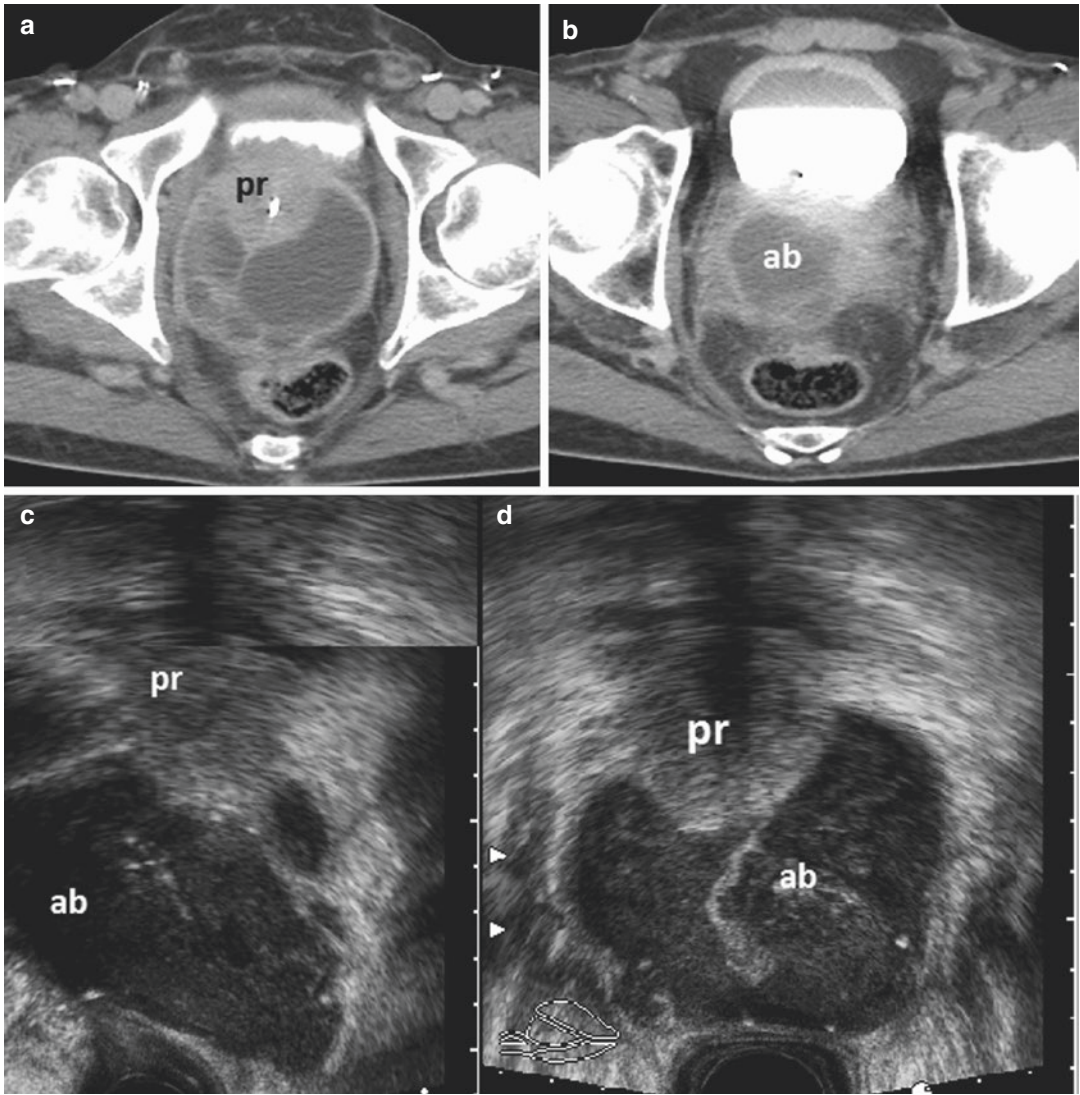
Prostatic abscess (*ab*) extending beyond prostatic capsule (*pr*) in the perirectal tissue at CT (a, b), TRUS (c, d), and the same case after 3 months follow-up after transperineal drainage (e, f longitudinal and axial view)
